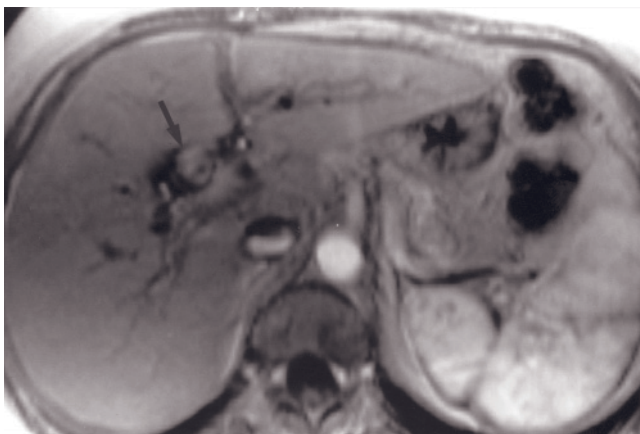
(Continued) T2-weighted image (*d*). The tumor shows poor conspicuity on the precontrast GE image (*e*). On the 2-min postgadolinium image (*f*), the small Klatskin tumor (arrow, *f*) in the porta hepatis demonstrates enhancement and can be well differentiated from surrounding structures.
